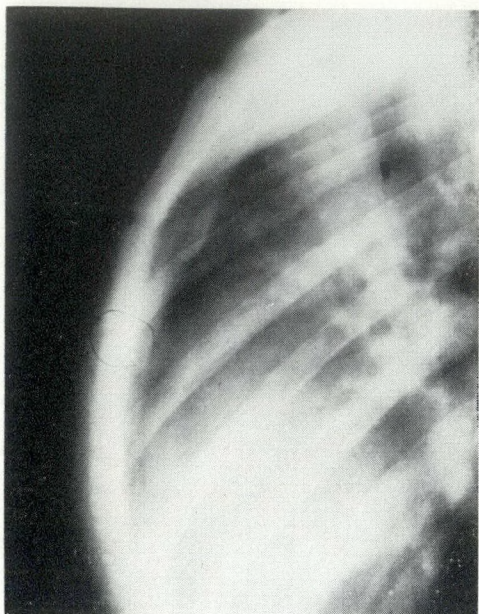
Case 2. Post-reduction radiograph.
